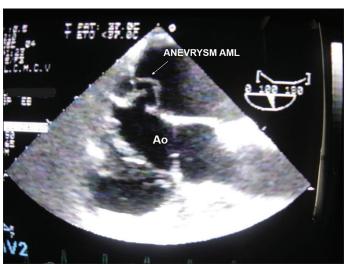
Transesophageal echocardiography, 100° view showing the aneurysm of the anterior mitral leaflet. Ao: Aorte
